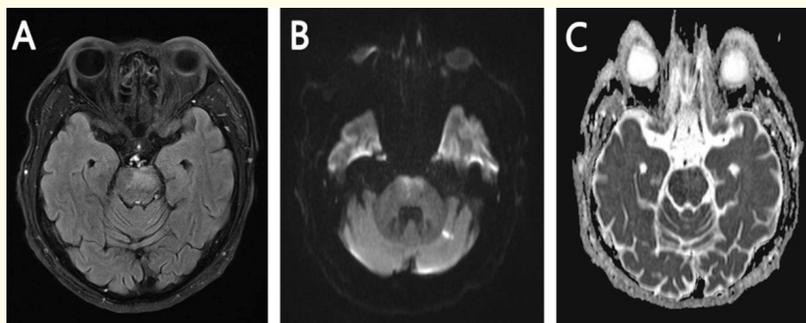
Follow-up MRI performed 14 days showed that previous high signal in the pons and cerebellar peduncle decreased in FLAIR MRI (A). Diffusion MRI and apparent diffusion coefficient (ADC) mapping showed iso-signal intensity at same regions (B, C).
